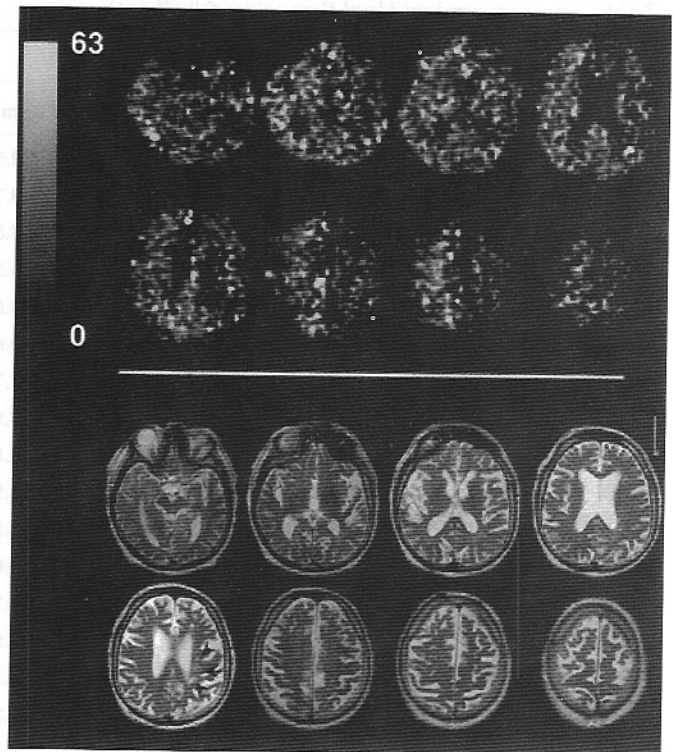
Cerebral blood flow (CBF) images and T2-weighted images from Patient 1. (Top) CBF is decreased both globally and asymmetrically, with markedly decreased flow in the left hemisphere, most notable in watershed regions. Grayscale shows CBF ranging from 0 to 63 mL/100 g/min. (Bottom) T2-weighted images show bilateral periventricular white matter changes. Arrows indicate asymmetric ischemic changes in the subcortical white matter that are likely the sequelae of hypoperfusion.
